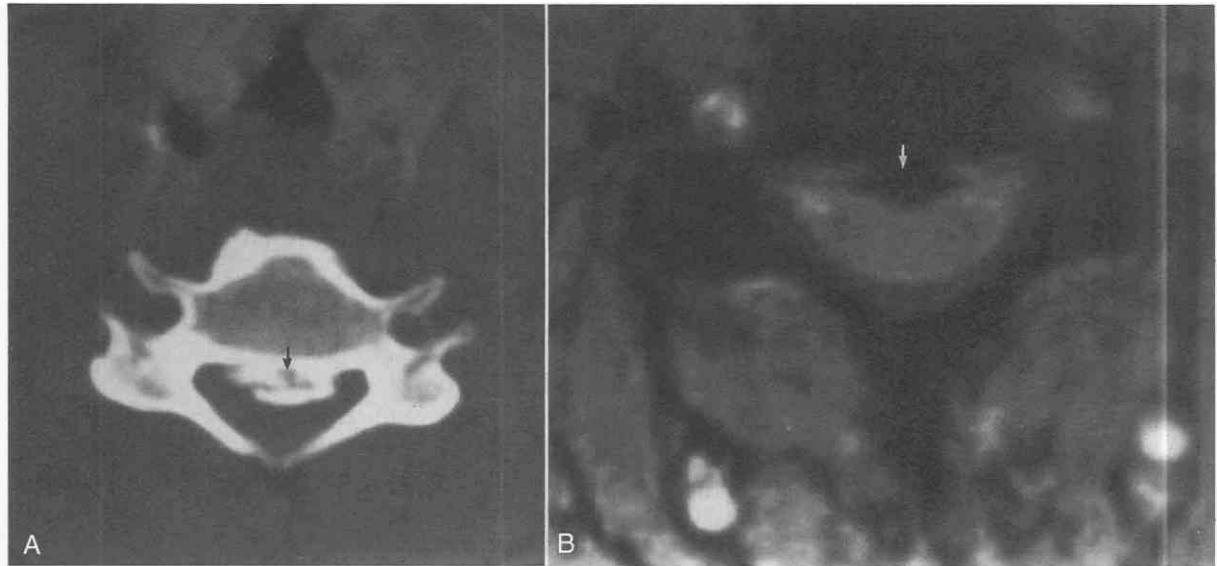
Ossified posterior longitudinal ligament. Axial noncontrast CT scan (A) and axial gradient-echo MR image (B) show the ossified ligament (arrows) impinging on the spinal canal.
